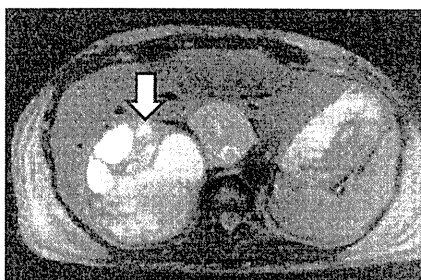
Magnetic resonance imaging showed a huge mass with high density and a relatively low-density area on T2W1 (arrow).
